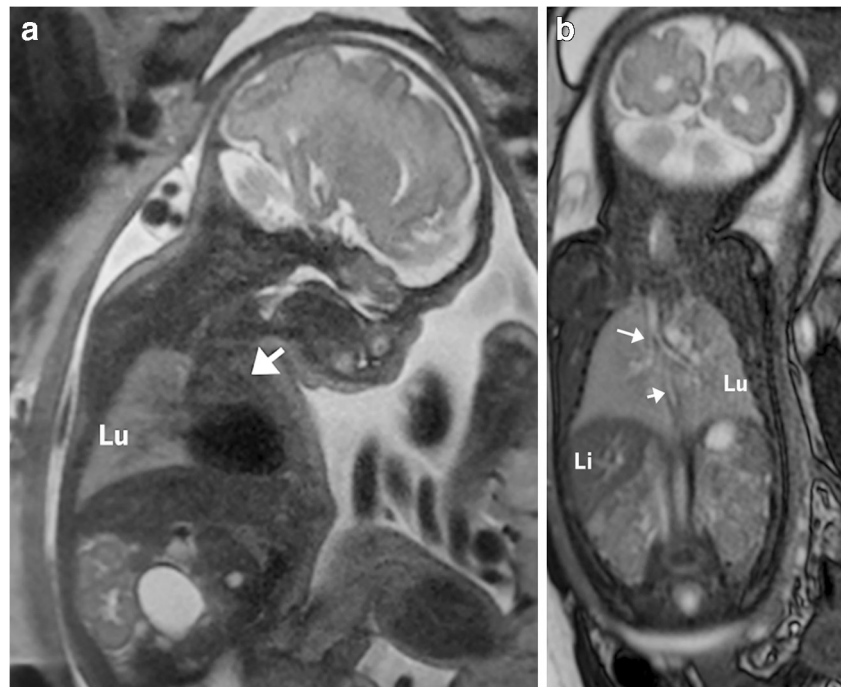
Normal sonographic fetal lung signal. a, b Sagittal (a) and axial (b) sonographic views of a 25-week fetus demonstrate normal homogeneously echogenic lung (*Lu*) with respect to liver (*Li*) and heart (*H*)
